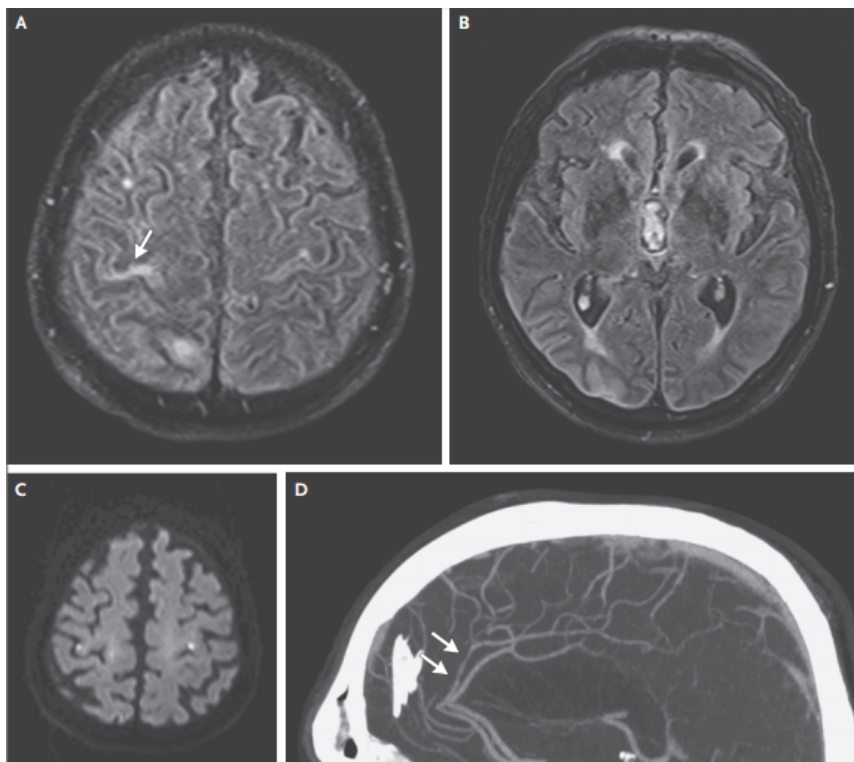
MRI of a case of meningoencephalitis associated with ZIKV. Fluid-attenuated inversion recovery was used. a, subcortical white-matter hyperintensities in the right frontal region, the right parietal region, bilateral rolandic regions and b, right temporo-occipital region. c, multiple punctuated hyperintensities on diffusion-weighted sequences that suggest ischemic foci. d, angiogram shows an irregular narrowing of the right callosomarginal artery [adapted from 97].
